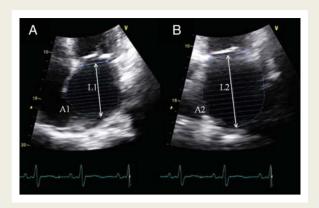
A representative images of the measurement of the left atrial (LA) volume. (A) Apical four-chamber view; (B) apical two-chamber view. Left atrial areas in the apical four- and two-chamber views (A1 and A2, respectively), and left atrial common long axis (L) can be measured. Left atrial common long axis (L) is the smaller one between L1 and L2. LA volume was calculated using area-length method and modified Simpson's method.
